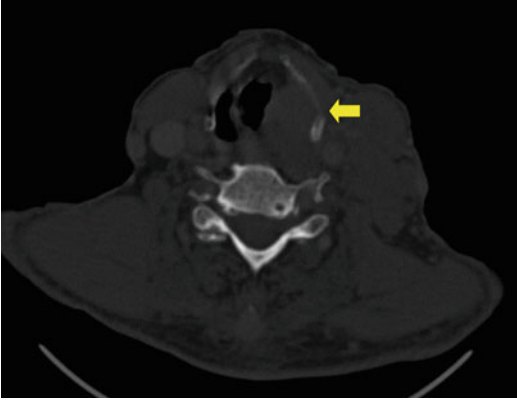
Contrast-enhanced CT neck (bone window) showing a pyriform fossa tumor showing erosion of the inner lamina of the thyroid cartilage without exolaryngeal spread (arrow)
